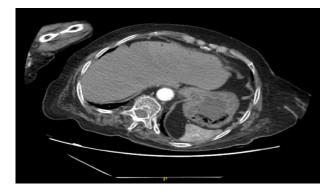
CT abdomen axial view.
